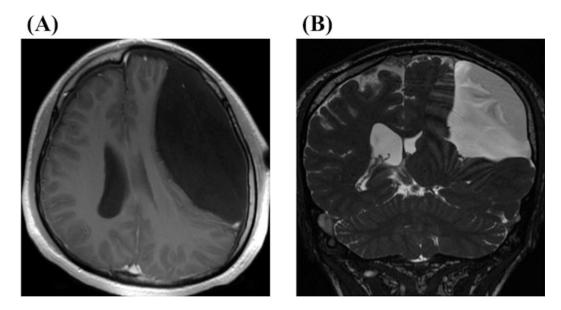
A 22-year-old male complained of headache and unsteadiness presented with a huge convexity arachnoid cyst at the parietal region. MRI (A; axial section on T1WI, B; coronal section on FIESTA) showed that the arachnoid cyst revealed marked compression on the adjacent cerebral parenchyma and ipsilateral lateral ventricle. His symptoms were completely disappeared after endoscopic fenestration between the cyst and the surrounding subarachnoid space.
